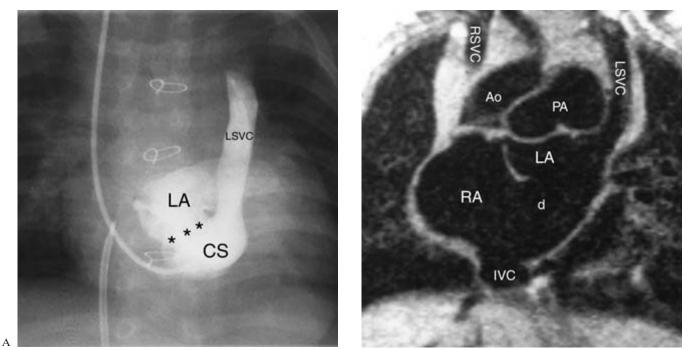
4 Unroofed coronary sinus. A. Injection into the left superior vena cava (LSVC) opacifies the coronary sinus (CS) and shunting of contrast medium into the left atrium (LA) thorough the defect (asterisks) in the party wall between the coronary sinus and left atrium. B. MR image in a coronal plane shows complete unroofing of the coronary sinus. As the result, the left superior vena cava connects to the roof of the left atrium and the coronary sinus opening functions as a large atrial septal defect (d). This complex is called coronary sinus defect or Raghib defect. Ao, aorta; IVC, inferior vena cava; PA, pulmonary artery; RSVC, right superior vena cava.
